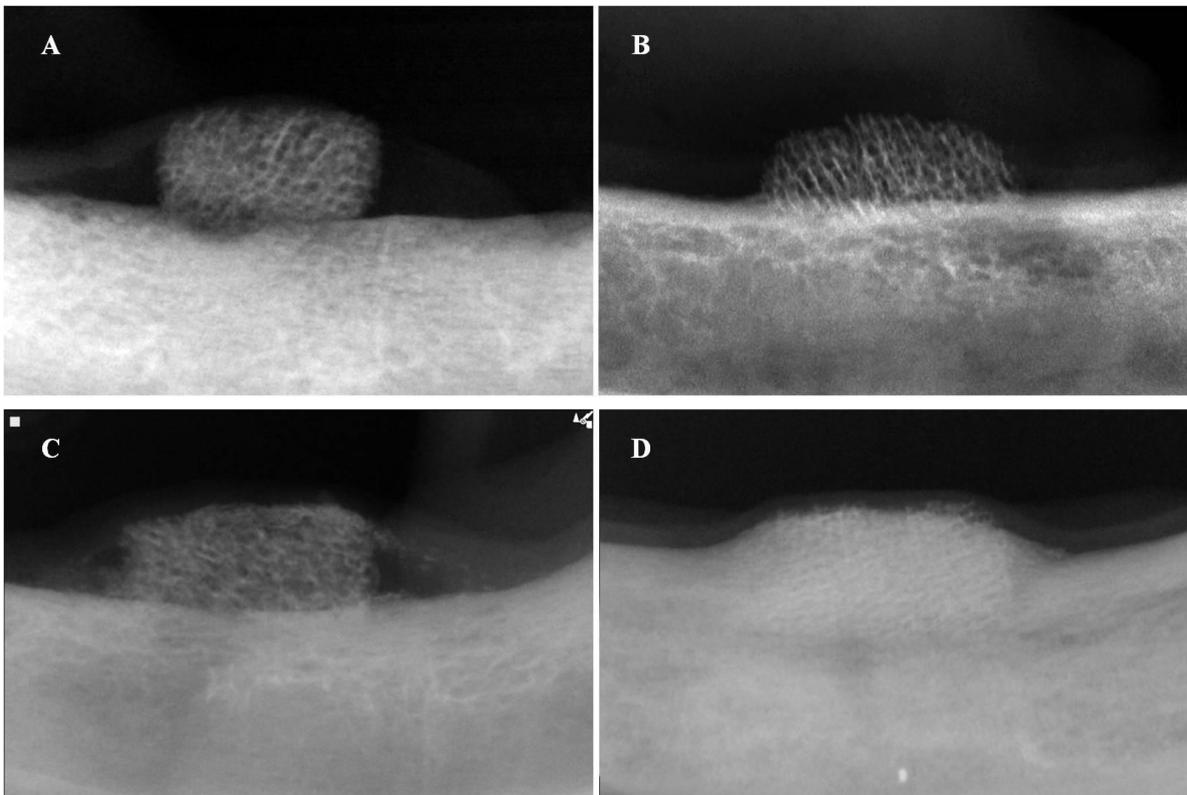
Radiographic evidence of ossification in the blocks. A: Immediately after the flap procedure, B: Six months after the flap procedure, C: Immediately after the tunneling procedure, D: Six months after the tunneling procedure.
